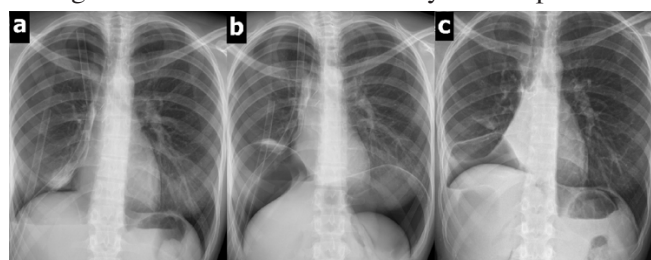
Chest x-rays; before the pneumoperitoneum (a), just after the pneumoperitoneum (b), at the time of discharge (c).
